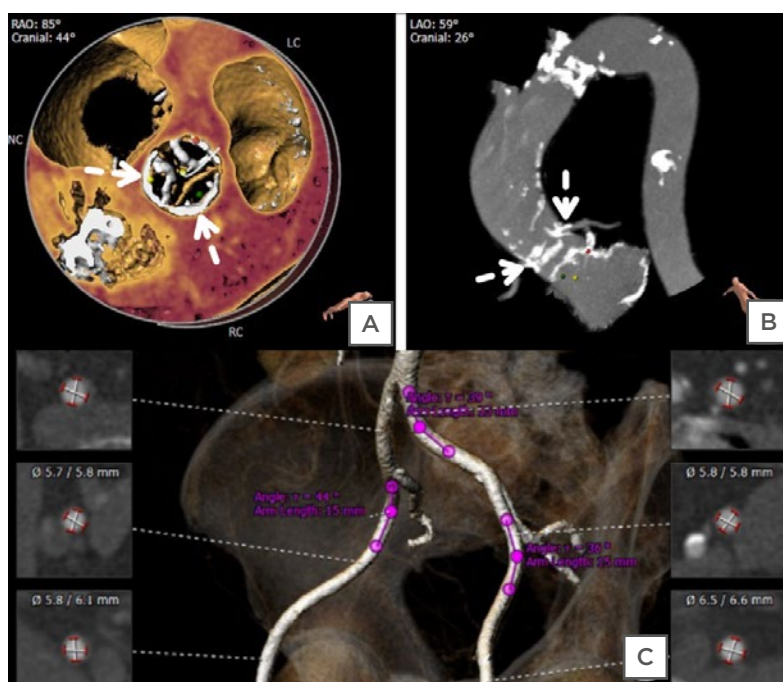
Computed tomography of the ascending aorta.
